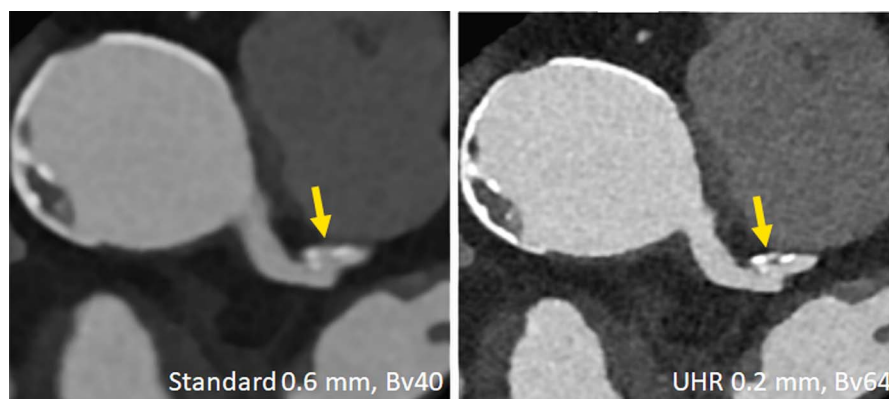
Clinical example demonstrating improved characterization of coronary plaques with UHR PCD-CT. A plaque that appears essentially calcified in a standard reconstruction (left) turns out to be mixed and smaller in volume in the UHR image (right). Image courtesy of Drs V. Mergen and H. Alkadh, University Hospital Zurich, Switzerland.
